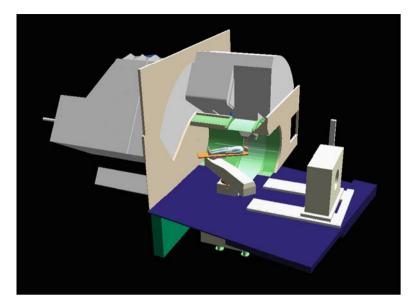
The new layout of Gantry 2 (G2), with limited rotation from -30° to $+185^{\circ}$, fixed environment of the patient table and integration of a sliding CT
